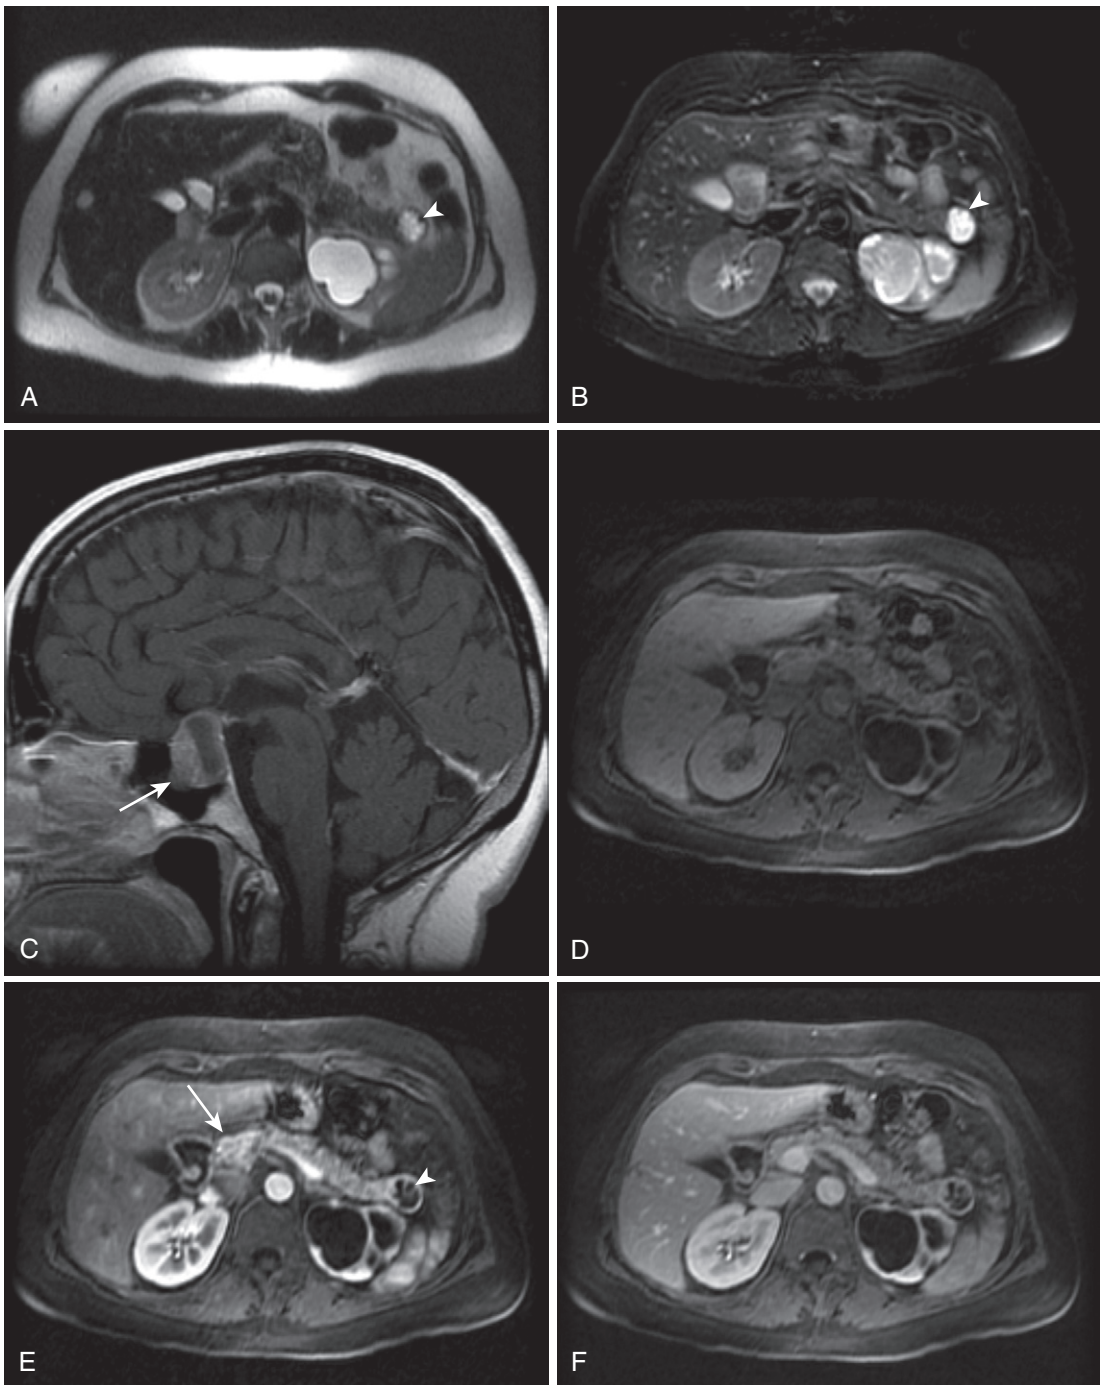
Islet cell tumor. T2-weighted (A), fat-suppressed T2-weighted (B), and dynamic precontrast (D), early arterial phase (E), and late arterial phase (F) 3-D fat-suppressed T1-weighted gradient recalled-echo images demonstrate two arterial enhancing lesions in the pancreas. The solid lesion (*arrow*) is best appreciated on the early arterial phase image (E), and the cystic lesion (*arrowhead*) is best identified on the fat-suppressed T2-weighted image (B). These lesions in a patient with a pituitary adenoma (identified on the sagittal T1-weighted image [C] of the brain [*arrow*]) and a known parathyroid adenoma are solid and cystic islet cell tumors in the setting of multiple endocrine neoplasia (MEN)-I or Wermer's syndrome.
